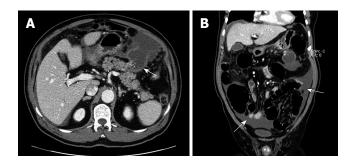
CT scan of case 1 showing a 5 cm-sized ruptured cystic mass in the pancreatic body and tail junction (arrow) (A) and massive ascites throughout the peritoneal space (arrow) (B).
